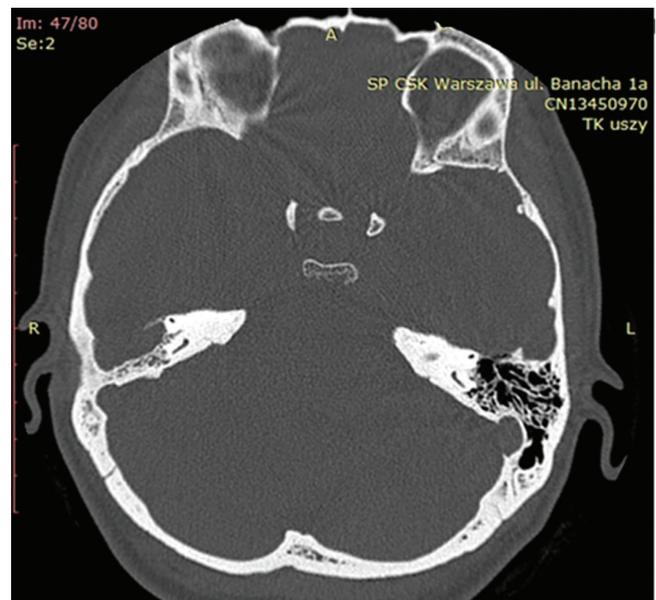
CT scan, axial view, showing the bony defect of the middle cranial fossa floor
